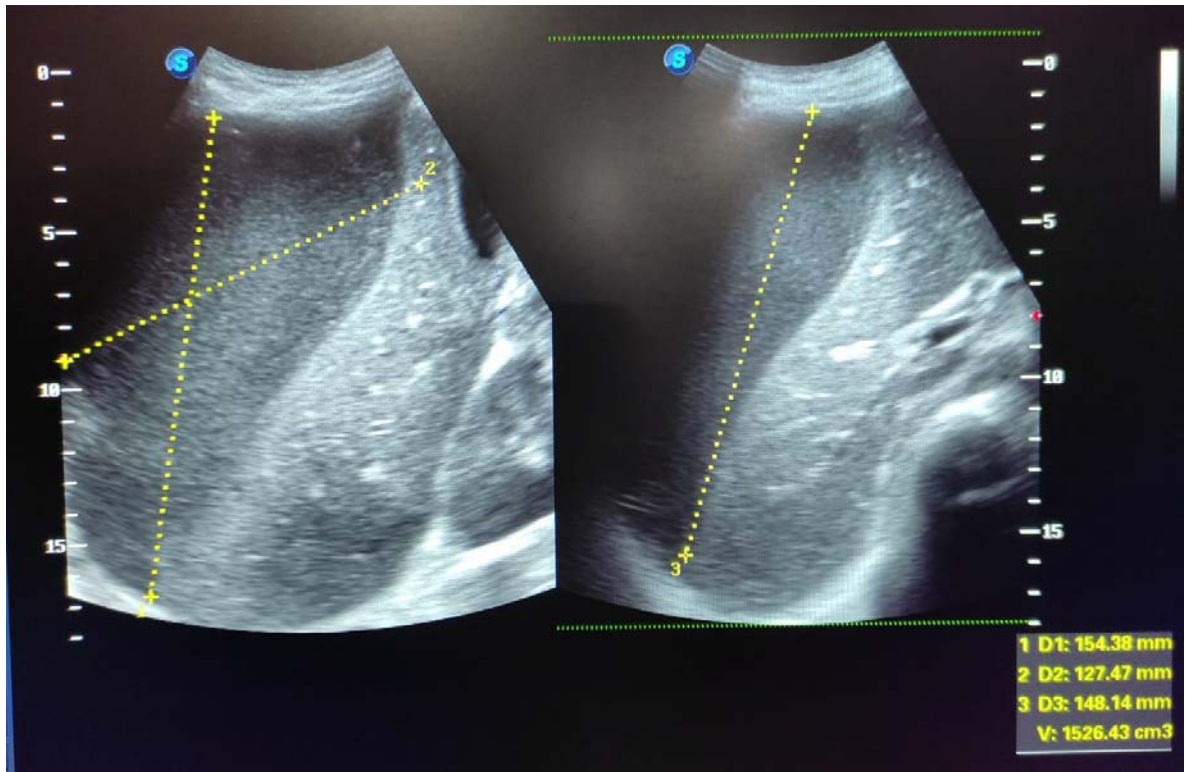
Ultrasonography of abdomen showing 1500cc right sub-phrenic collection pushing liver down.
